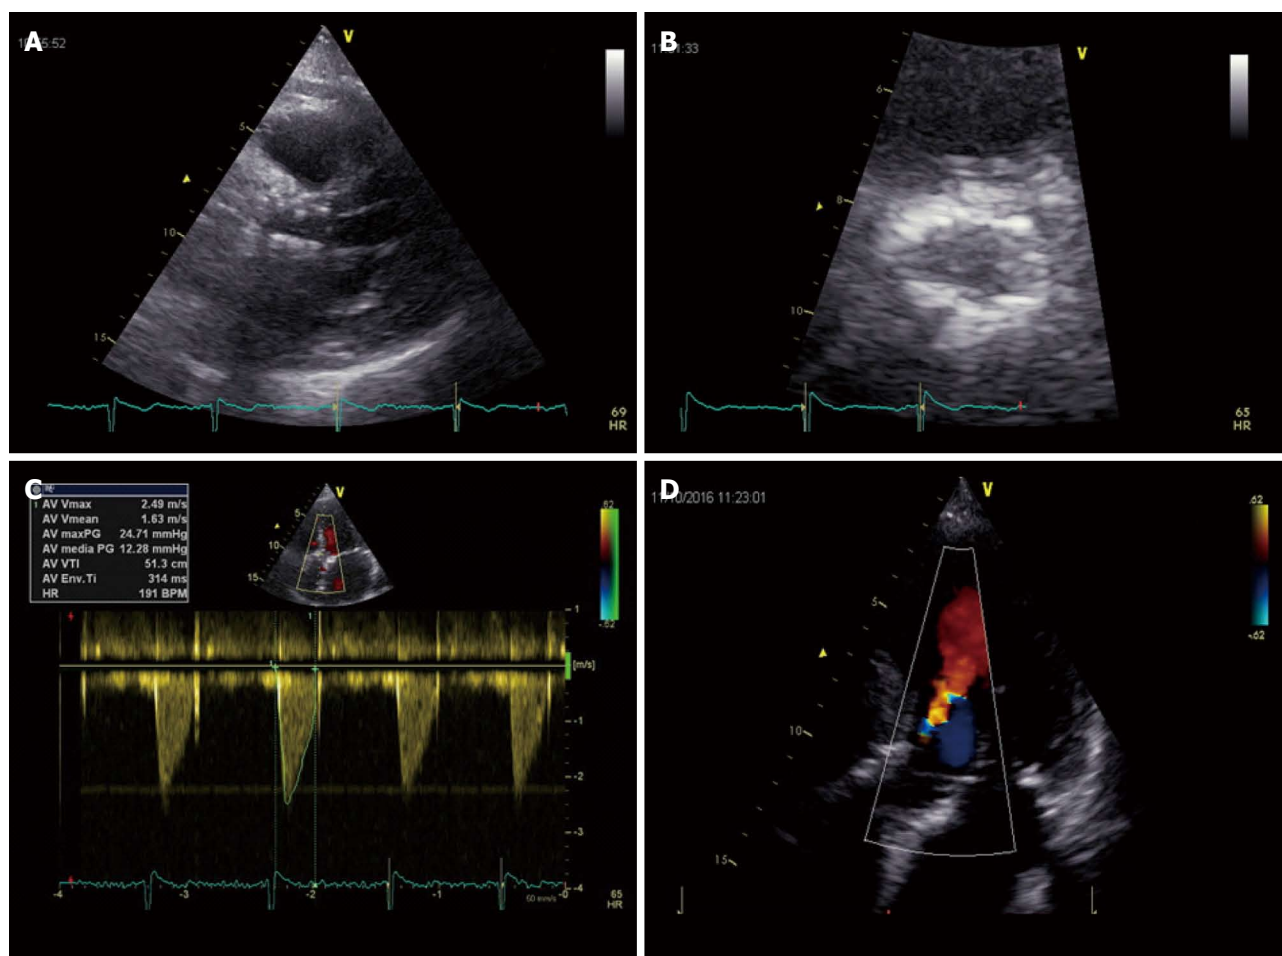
Post-implantation echocardiographic transcatheter aortic valve replacement assessment in long-axis (A) and short-axis (B) parasternal views; Normal trans-prothesis flow gradient by Doppler analysis (C); Mild paravalvular aortic regurgitation in this apical 5-chamber view of the same patient (D).
